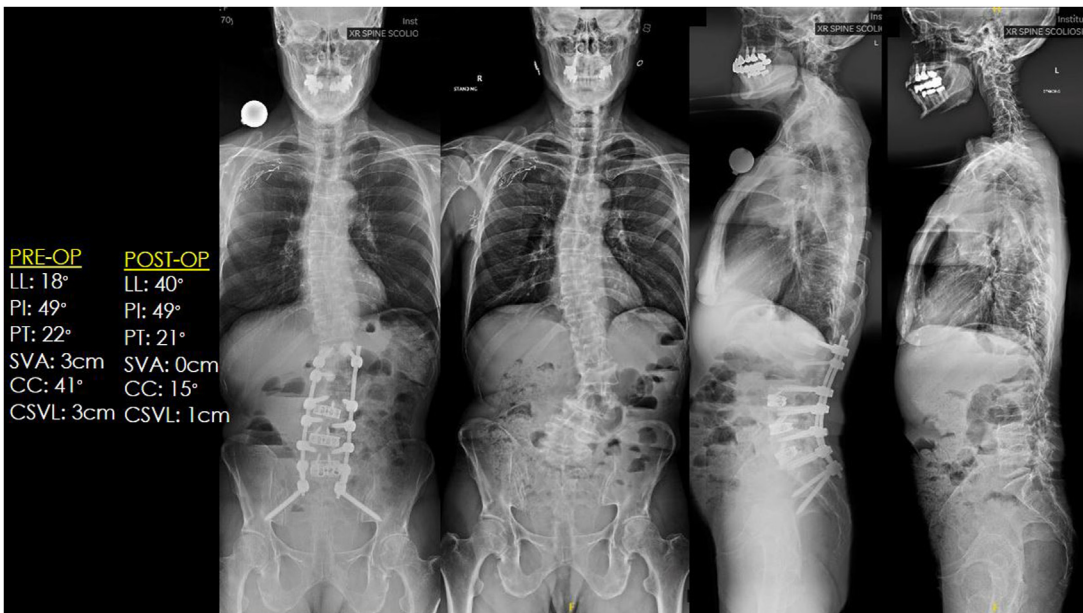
Preoperative and postoperative standing radiographs for example, case 2 demonstrating a MISDEF class 3.
